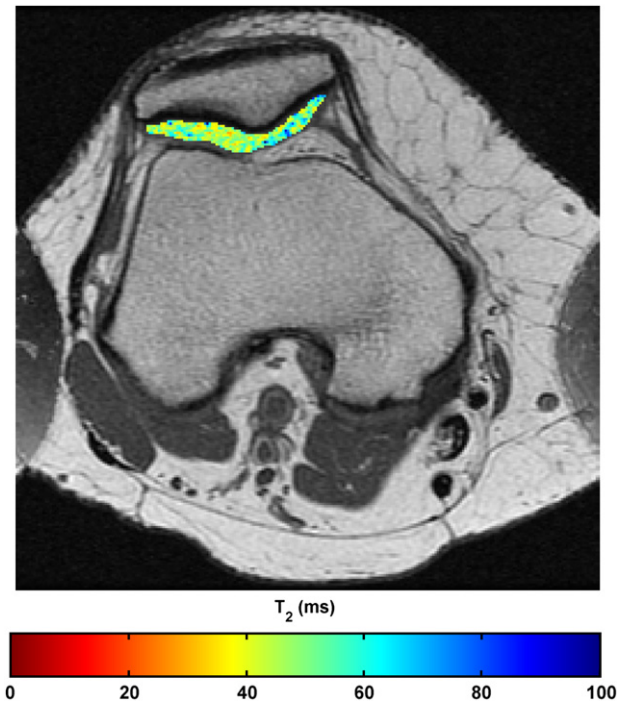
A representative T_2 map of patellar cartilage superimposed on the first echo image for a subject graded as KL OA grade 1. Even graded radiographically as mild OA, elevated T_2 values are found near the subchondral bone–cartilage interface as well as near the articular surface on the medial aspect of the patella.
